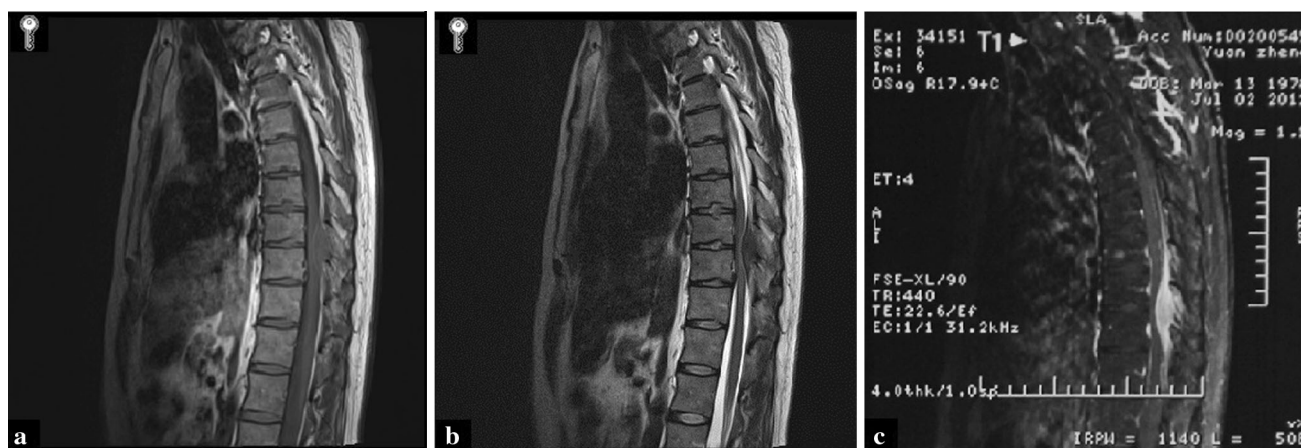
Magnetic resonance imaging of the thoracic spine demonstrating a well-defined epidural mass extending from the T9–T10 levels. a Sagittal T1-weighted images demonstrating a iso-intense
